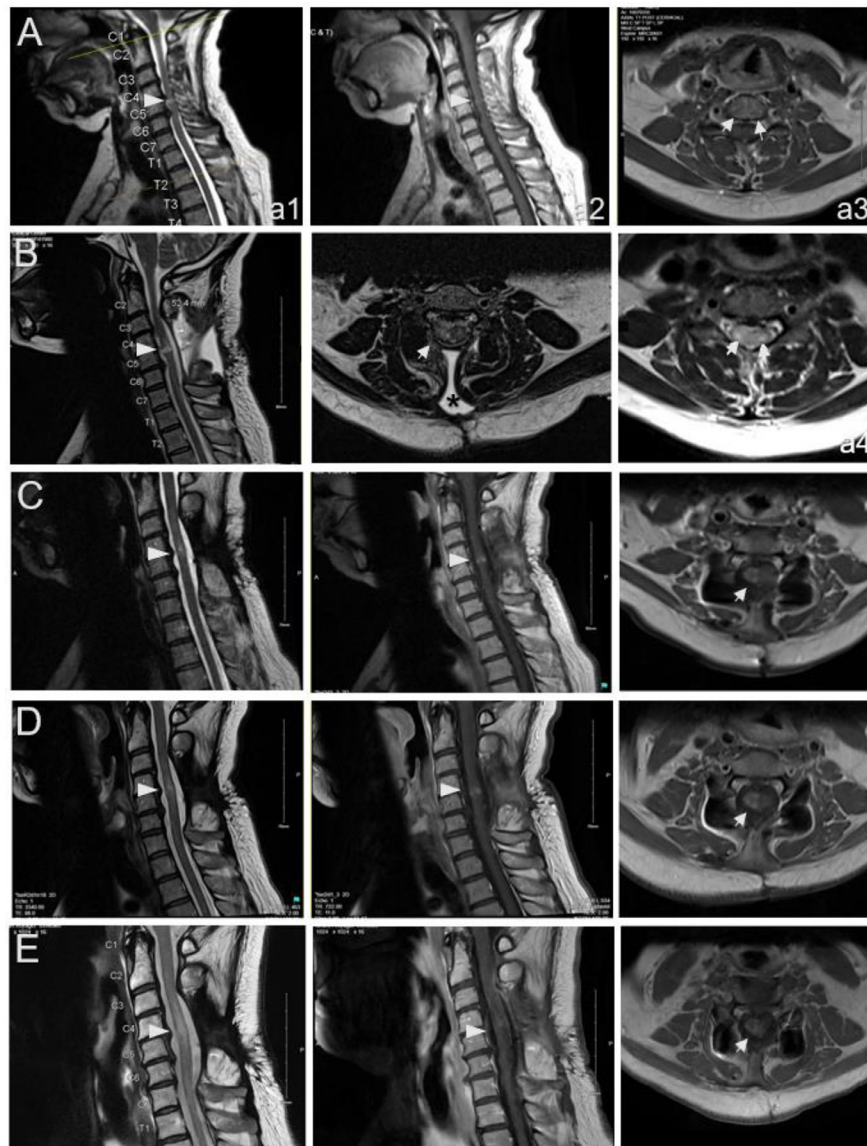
Progression of T2-weighted changes and persistence of enhancement on cervical MRI of the spine. (A) Spinal MRI prior to surgery showed intervertebral disc bulge with flattening of the spinal cord at multiple levels of the cervical spine, worst at C4-C5 and C5-C6. T2-weighted, sagittal image shows hyperintensity in the cord at this level (arrowhead in a1), with no apparent enhancement following contrast administration on T1-weighted sagittal (arrowhead in a2) and axial (arrows in a3). Corresponding T2-weighted axial image shows right greater than left hyperintensities (arrows in a4). (B) Two months later, spinal MRI showed postsurgical changes related to posterior decompression and instrumented fusion at C3-C6 and re-demonstration of right greater than left T2-weighted hyperintensity in the spinal cord at C4-C5 level on sagittal (arrowhead) and axial (arrow) images. The hyperintensity at this level was not significantly changed in the right aspect of the spinal cord (arrow), however it appeared improved in the left aspect of the spinal cord compared to the preoperative MRI. Postsurgical changes with seroma formation (asterisk) were also appreciated. No contrast scan were obtained at this time. (C) Eleven months later, sagittal T2-weighted spinal MRI showed hyperintensity of the cord spanning C3 through C5 (arrow). To the right, sagittal (arrowhead) and axial (arrow) postcontrast T1-weighted images showed focal enhancement along the periphery of the right hemicord at C4-C5, which was new since the previous contrasted pre-surgical examination and was thought to reflect enhancing scar tissue and/or revascularization. (D) Thirteen months later, sagittal T2-weighted spinal MRI showed similar intramedullary cord signal abnormality spanning C3-C6 but most prominent at the C4-C5 intervertebral disc level (arrow), likely reflecting progression of myelomalacia. Heterogeneous postcontrast enhancement centered at C4-C5 (arrow) was still seen on sagittal (arrowhead) and axial (arrow) postcontrast T1-weighted images. (E) Nineteen months later, sagittal T2-weighted spinal MRI showed continued progression and increase in the spinal cord signal hyperintensity (arrow). To the right, the postcontrast enhancement on T1-weight sagittal (arrowhead) and axial (axial) images at the C4-5 level persisted despite no spinal cord encroachment, but was improved from prior.
